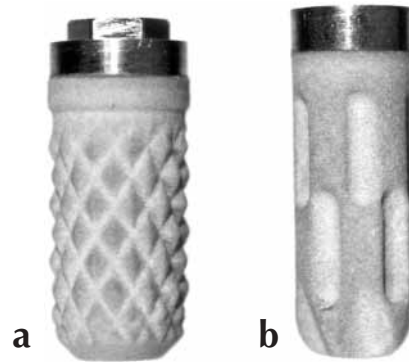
(a) Matrix-like pattern on body of Bioclock IHSSHA410 implant could appear as pseudo-threads on radiograph. (b) Multiple grooves on body of Parc Press-fit V057 could appear as pseudo-threads on radiograph.
